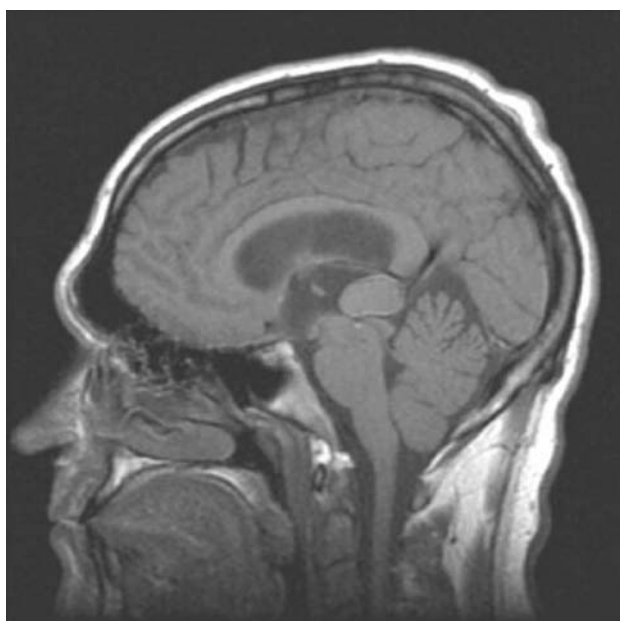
Brain magnetic resonance imaging (MRI) of a 40-year old patient showing pineal gland tumour with compressive effect.
